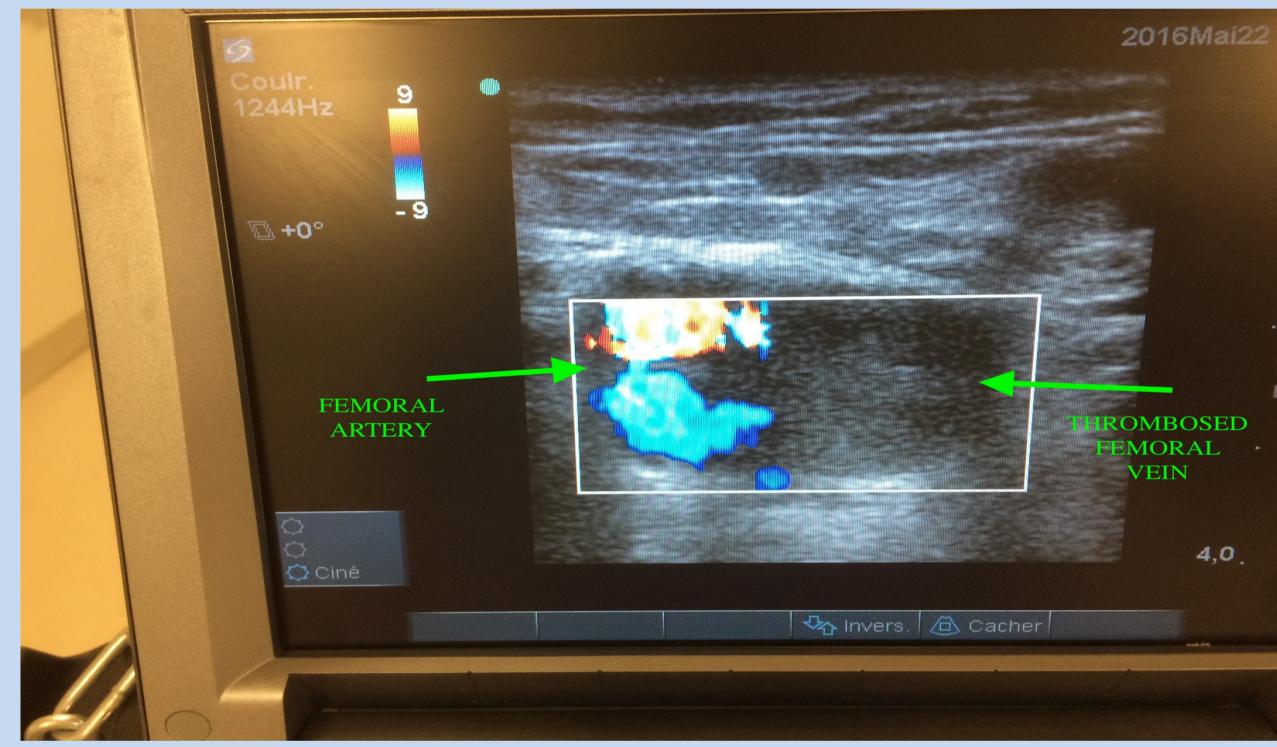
ultrasound image of venous thrombosis and persistent arterial flow ©NCazes
